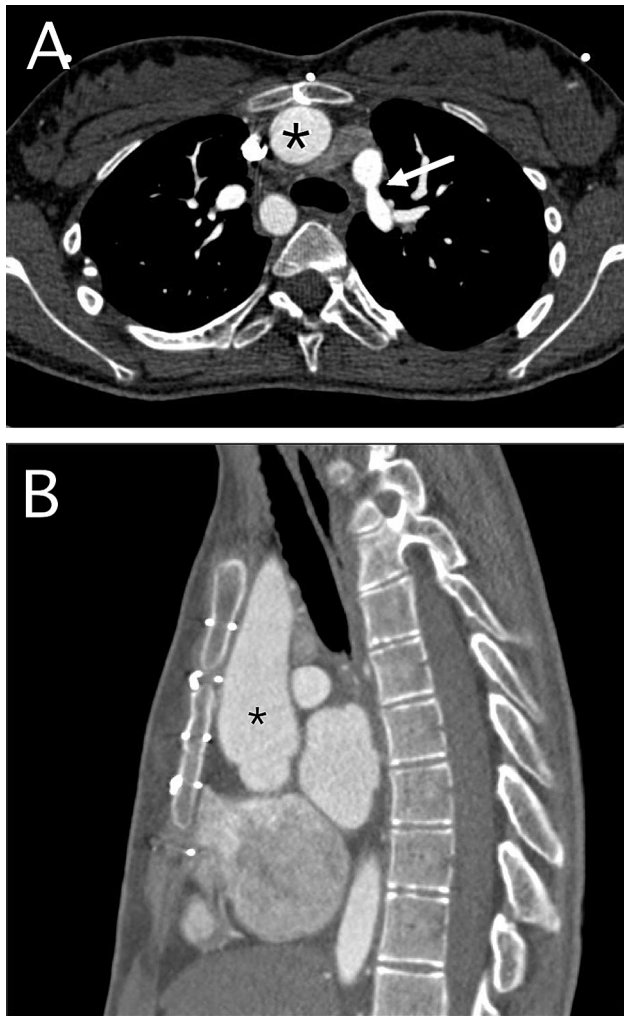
Preoperative angiographic CT scan showing (A) a transverse cross section and (B) a longitudinal cross section of an ascending aorta adhering to the sternum (black asterisk). The white arrow shows the left pulmonary artery ostial stenosis.
